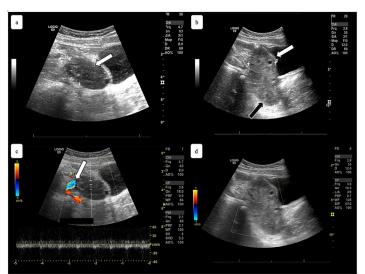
a) Sagittal view of the patient's left ovary on transabdominal pelvic ultrasound, measuring $4.4 \times 2.4 \times 2.0$ centimeters (cm), indicating a slightly enlarged but otherwise normal ovary (white arrow); b) sagittal view of the patient's right ovary with measurements of $8.7 \times 1.3 \times 6.1$ cm, demonstrating an abnormally enlarged ovary (white arrow) with a heterogenous mass (black arrow); c) sagittal view of the patient's left ovary with normal color flow Doppler (white arrow); d) sagittal view of the patient's right ovary demonstrating lack of blood flow on color flow Doppler.
